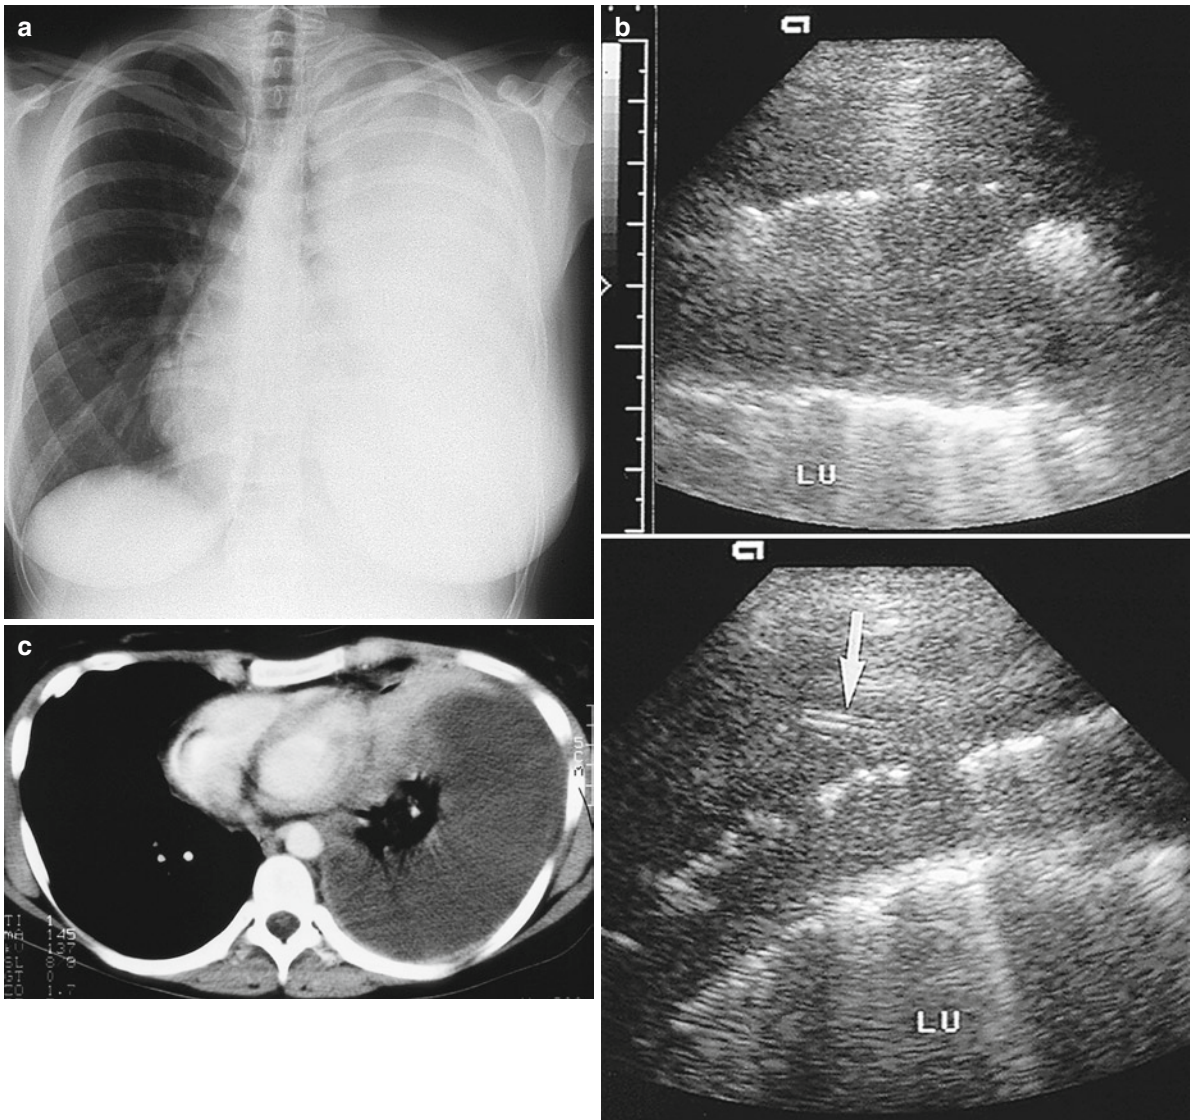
A 34-year-old man with pulmonary blastoma. (a) Chest radiograph. Nearly complete opacity of lung parenchyma on the left side. (b) Ultrasonography. The lateral intercostal ultrasound beam transmission on the left side shows, in the caudal section (*left image*), a tumor (*TU*) that is completely infiltrating the basal diaphragmatic
